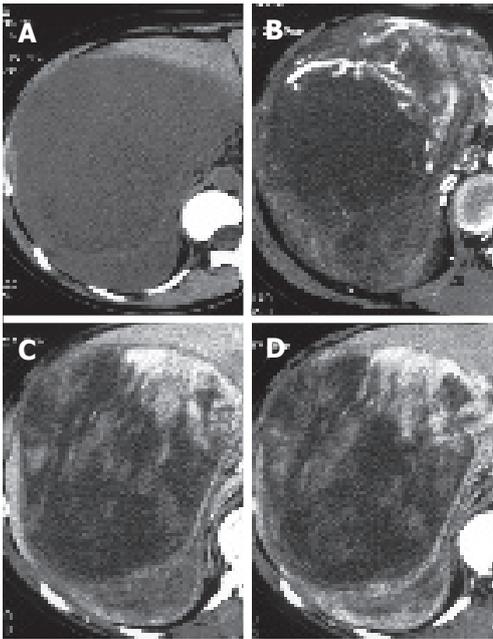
Preoperative dynamic CT images. A: plain; B: early phase; C: delayed phase; D: late phase. The tumor detected as a low density area and occupied the right hepatic lobe and the peritoneal cavity (A). Dynamic study revealed that the tumor enhanced irregularly at any phase (B-D).
